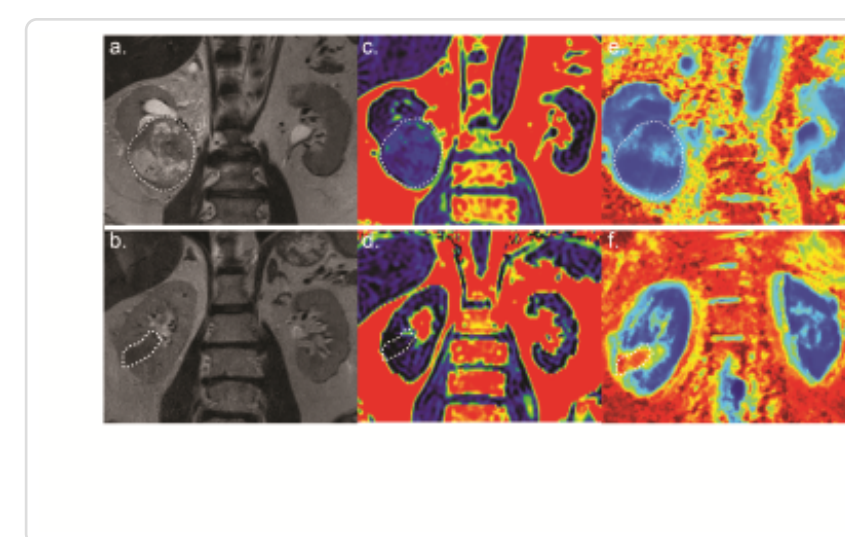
Coronal MRI images of two patients with clear cell RCC (top row) and papillary RCC (bottom row). (a & b) T2-weighted; (c & d) proton density fat fraction; (e & f) VERDICT-derived intracellular volume fraction (fIC).
